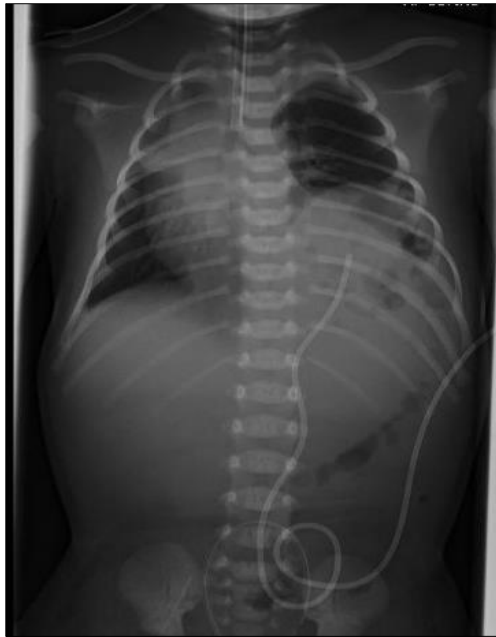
Chest x-ray before surgery
